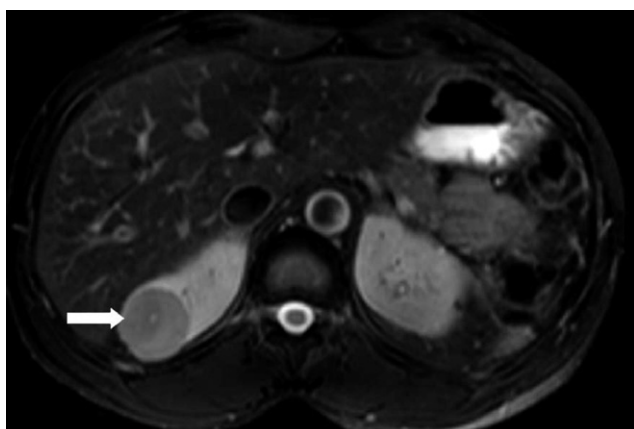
Sporadic papillary RCC. Axial, fat-suppressed T2-weighted MRI of a right papillary RCC (arrow) demonstrates a homogeneously hypointense solid mass.
